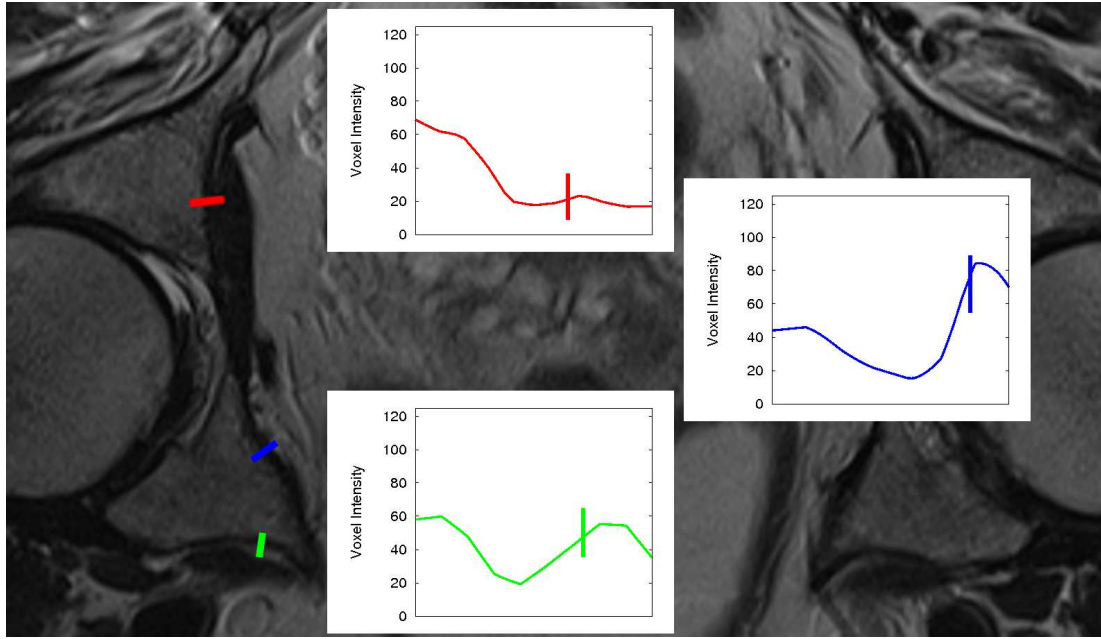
Shown here is a single slice of T2 weighted MRI. Three example profiles have been made across the bone edge. The vertical lines across each profile indicate our estimate of where the bone edge lies. Even within this single slice the intensity profiles across the edges are variable. Across the full pelvic bone and between different patients we expect even greater variance. Hence our decision to use shape constrained registration.
